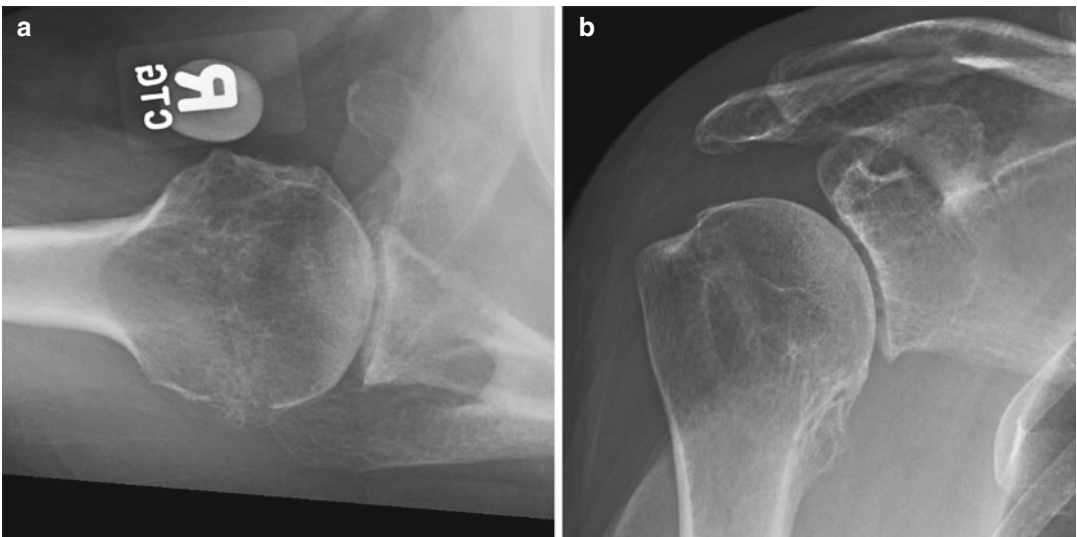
Right shoulder postoperative (a) axillary and (b) Grashey radiographs of a 60-year-old woman with primary osteoarthritis who underwent AGR and was able to successfully return to horseback riding and ranching activities
